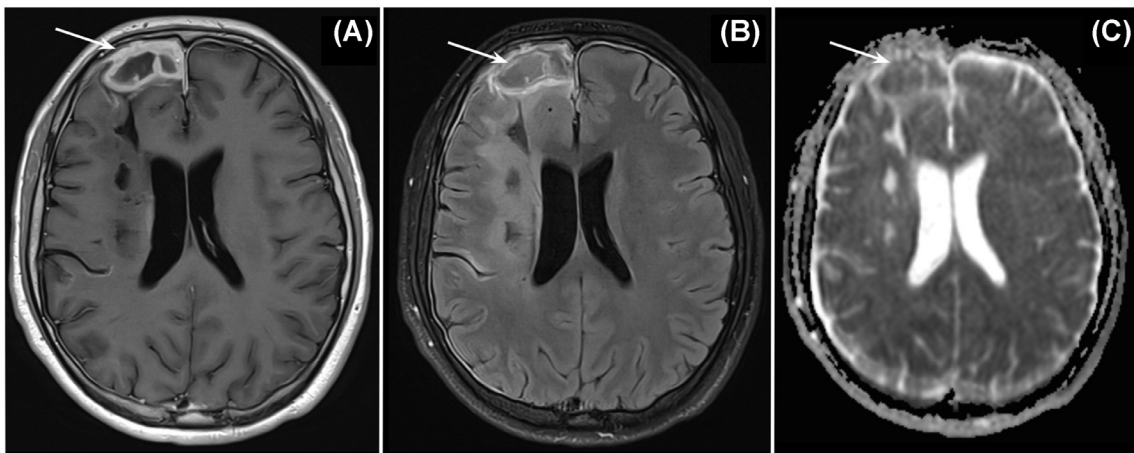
About 2 months post progress brain MRI with right frontal lobe thick-walled rim enhancing collection as seen on (A) T1 contrast enhance axial slice. Corresponding axial slice (B) FLAIR sequence with no hyperintensity and (C) Apparent diffusion coefficient (ADC) with no convincing central diffusion restriction to suggest persistent infection. Patient was managed non operatively and stepped down to oral antibiotics.
